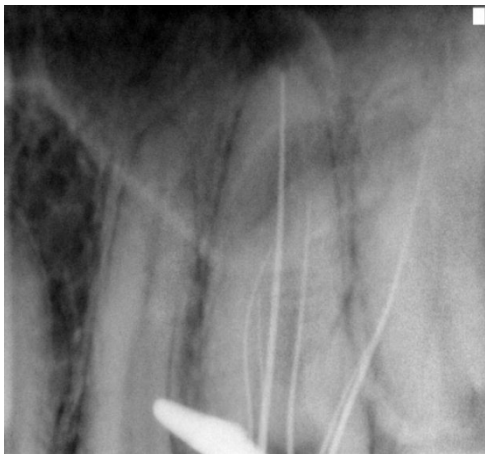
working length radiograph showing 6 canals
